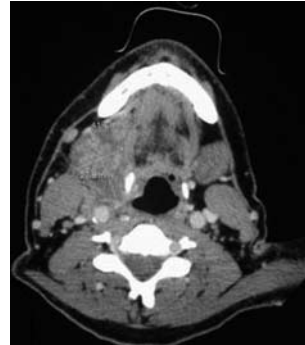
Contrast enhanced CT of the neck, showing a submandibular abscess.
